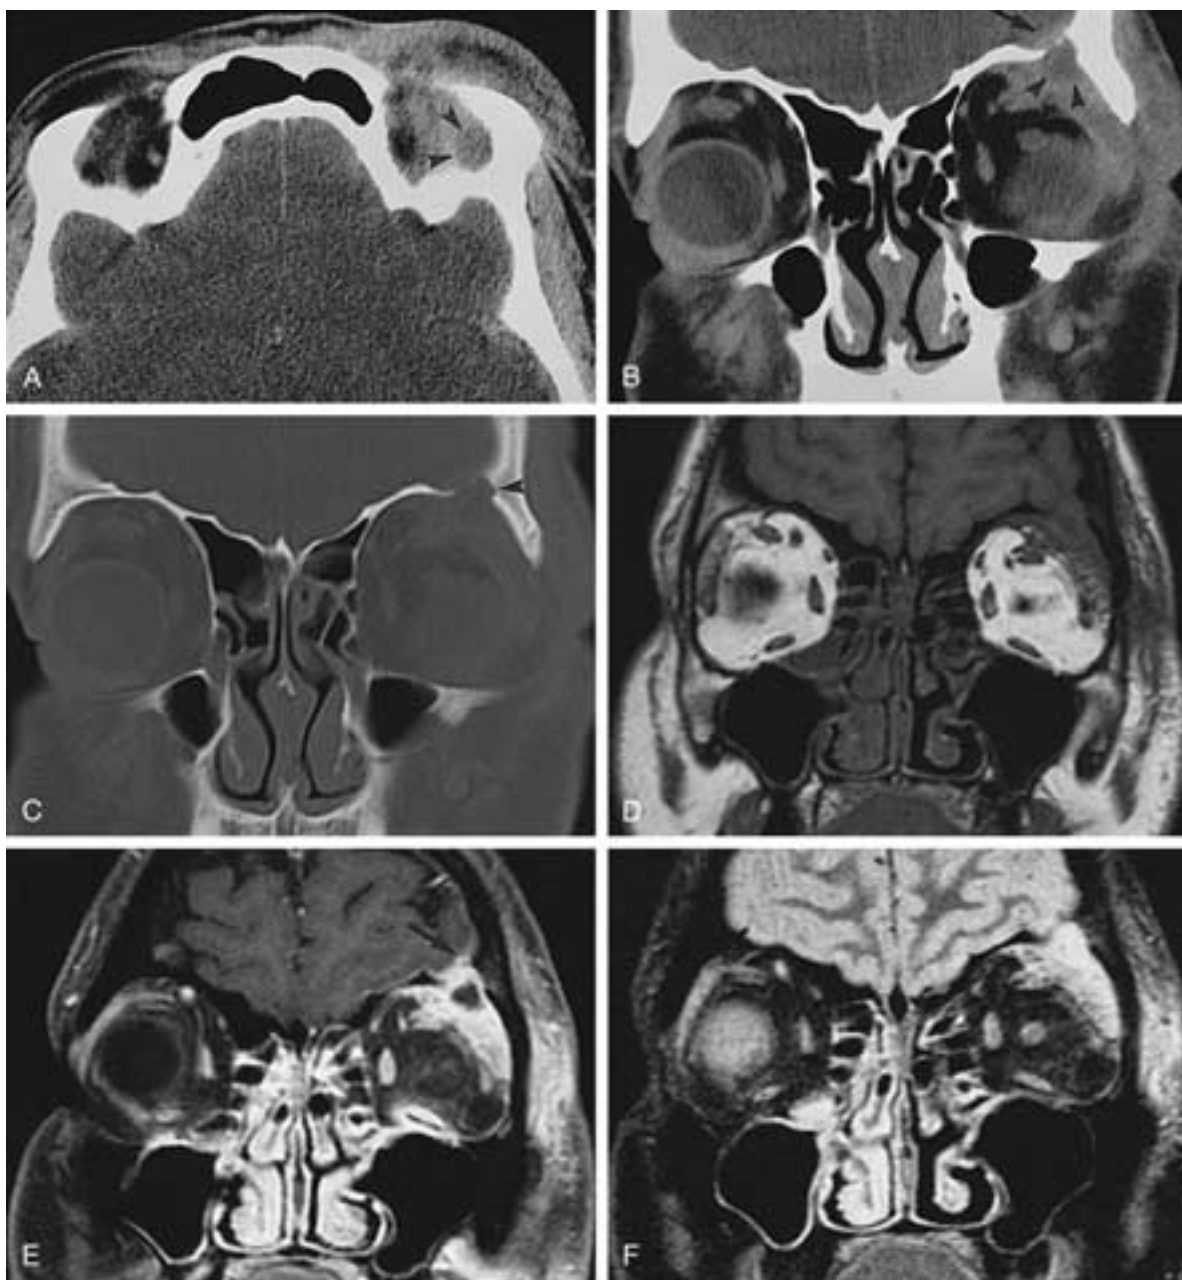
Nodular fasciitis. A 36-year-old man presented with an apparent inflammatory left orbital mass, which was unresponsive to 3 weeks of antibiotics. Axial (A) and coronal (B) contrast-enhanced CT. Soft-tissue windows show an ill-defined, enhancing, extraconal or subperiosteal soft-tissue mass in the left superior-lateral orbit, with a low-attenuation central area (*arrowheads*). Note the subtle enhancement along the anterior cranial fossa (*arrow*). C, Coronal CT bone windows demonstrate focal erosion in the frontal bone adjacent to this low-attenuation region (*arrowhead*). D, Coronal T1-weighted image (600/15) reveals an intermediate intensity extending lateral to the orbital rim in addition to eroding the frontal bone. E, Coronal, fat-saturation, postgadolinium, T1-weighted image (650/15). After gadolinium, most of the mass enhances, with a central, nonenhancing focus adjacent to the bone erosion. Note the intracranial dural reaction (*arrow*). F, Coronal, fast-STIR (2000/12/160) image. The mass is isointense to gray matter, with a focal area of hyperintensity corresponding to the cystic-appearing region on the postgadolinium image. The preoperative diagnosis was ruptured dermoid cyst or an aggressive lacrimal region abscess with osteomyelitis. (From Dalley RW. Fibrous histiocytoma and fibrous tissue tumors of the orbit. *Radiol Clin North Am* 1999;37:185–194.)
